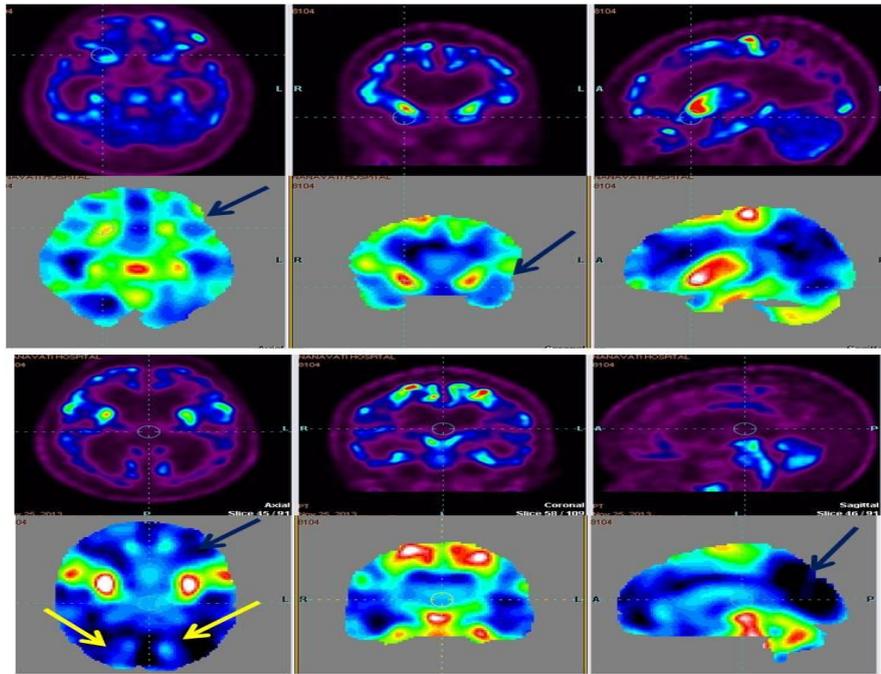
18F-FDG PET in a 8 year old autistic girl shows reduced FDG uptake in frontal, parietal and occipital lobes (blue arrows) and cerebellum (yellow arrows).
